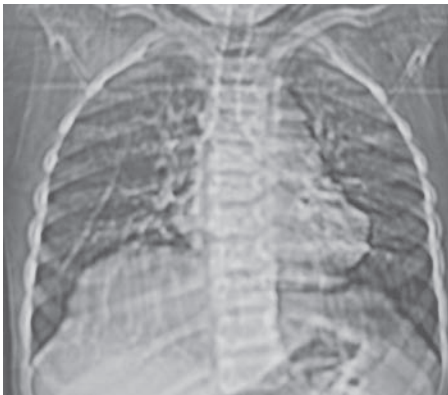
X-ray of the chest demonstrating tracheal calcification (Case 2).
